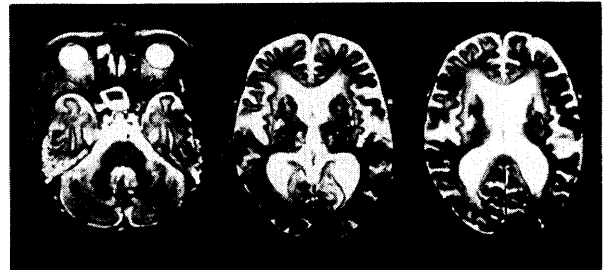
T2 weighted image (TR 3500 msec, TE 120 msec) of 1.5 Tesla MRI on day 23 shows widespread symmetrical hyperintensities involving the subcortical white matter of all but the occipital lobe, with thinning of the cerebral cortices. High-intensity lesions were also distributed on the white matter in the cerebellum. High-intensities on the center of pons were trivial compared with those seen in white matter. Pre-existing lacunar lesions on the basal ganglia and periventricular high-intensity areas that were seen on an earlier MRI study were detected.
